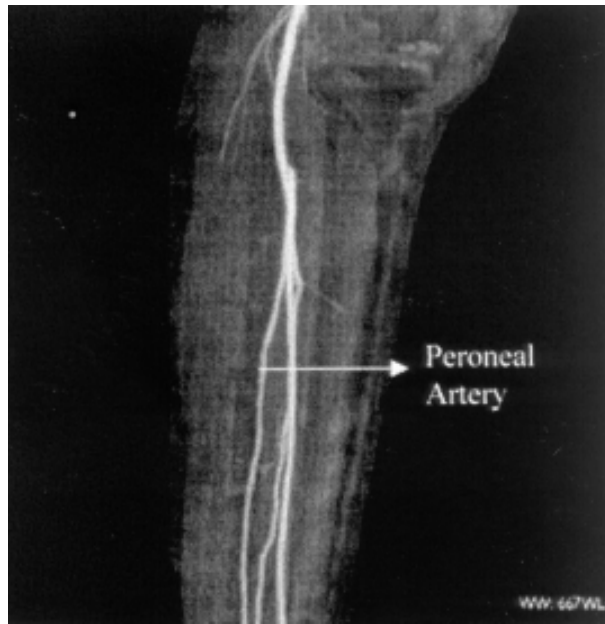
Above, Normal three-vessel runoff in lower extremity. Above right, CT angiogram demonstrating peroneal artery as dominant blood supply to the foot. Anterior tibial artery is occluded in proximal leg, and peroneal artery supplies dorsalis pedis artery. (Reprinted with permission from Karanas YL, Antony A, Rubin G, Chang J: Preoperative CT angiography for free fibula transfer. *Microsurgery* 24(2):125, 2004.)
